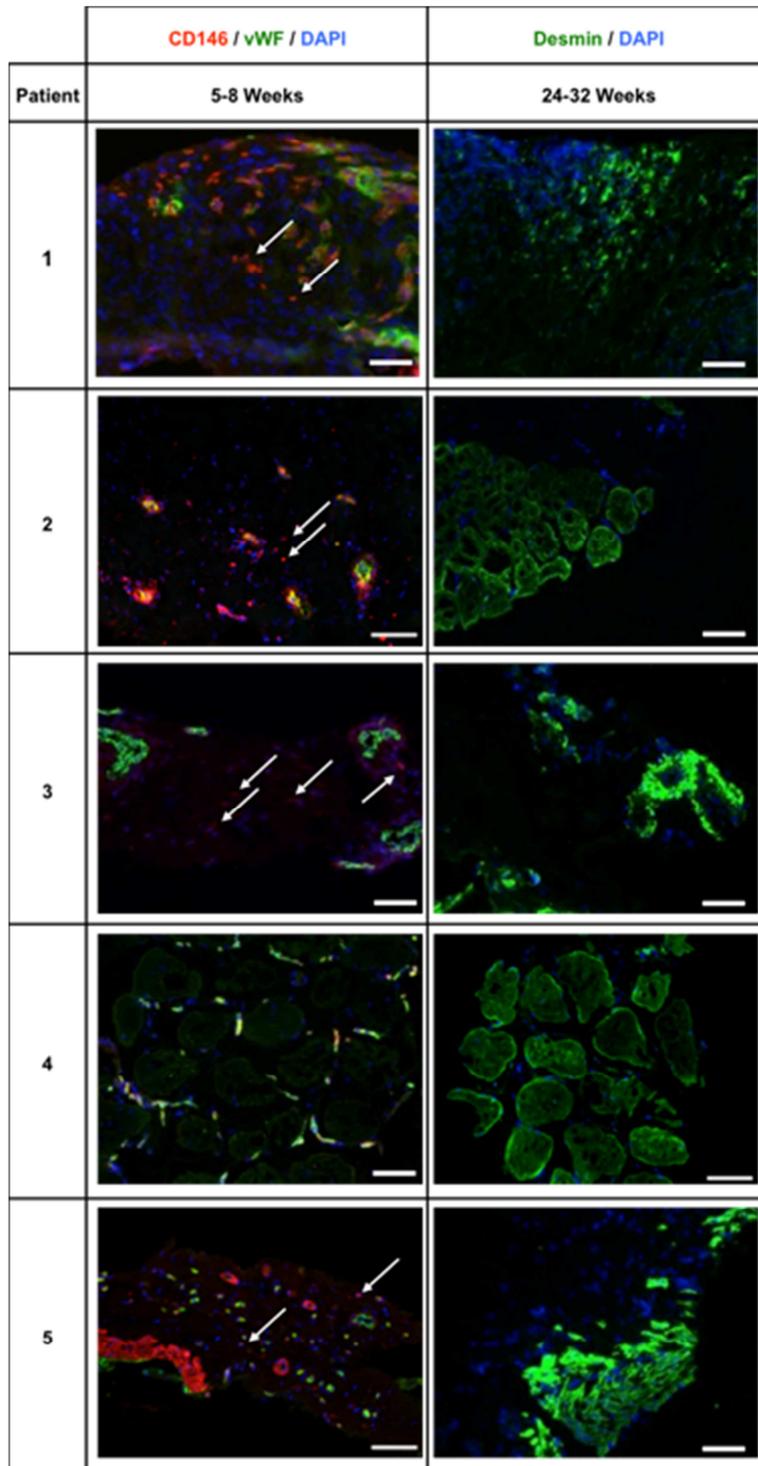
Histomorphology in human subjects with VML. Ultrasound-guided biopsies from each patient showing CD146+ PVSCs within and outside of (arrows) their typical perivascular niche 5-8 weeks after ECM scaffold implantation. Desmin+ muscle cells were present in biopsies from each patient 24-32 weeks after ECM scaffold implantation. Scale bars, 50 μ m.
